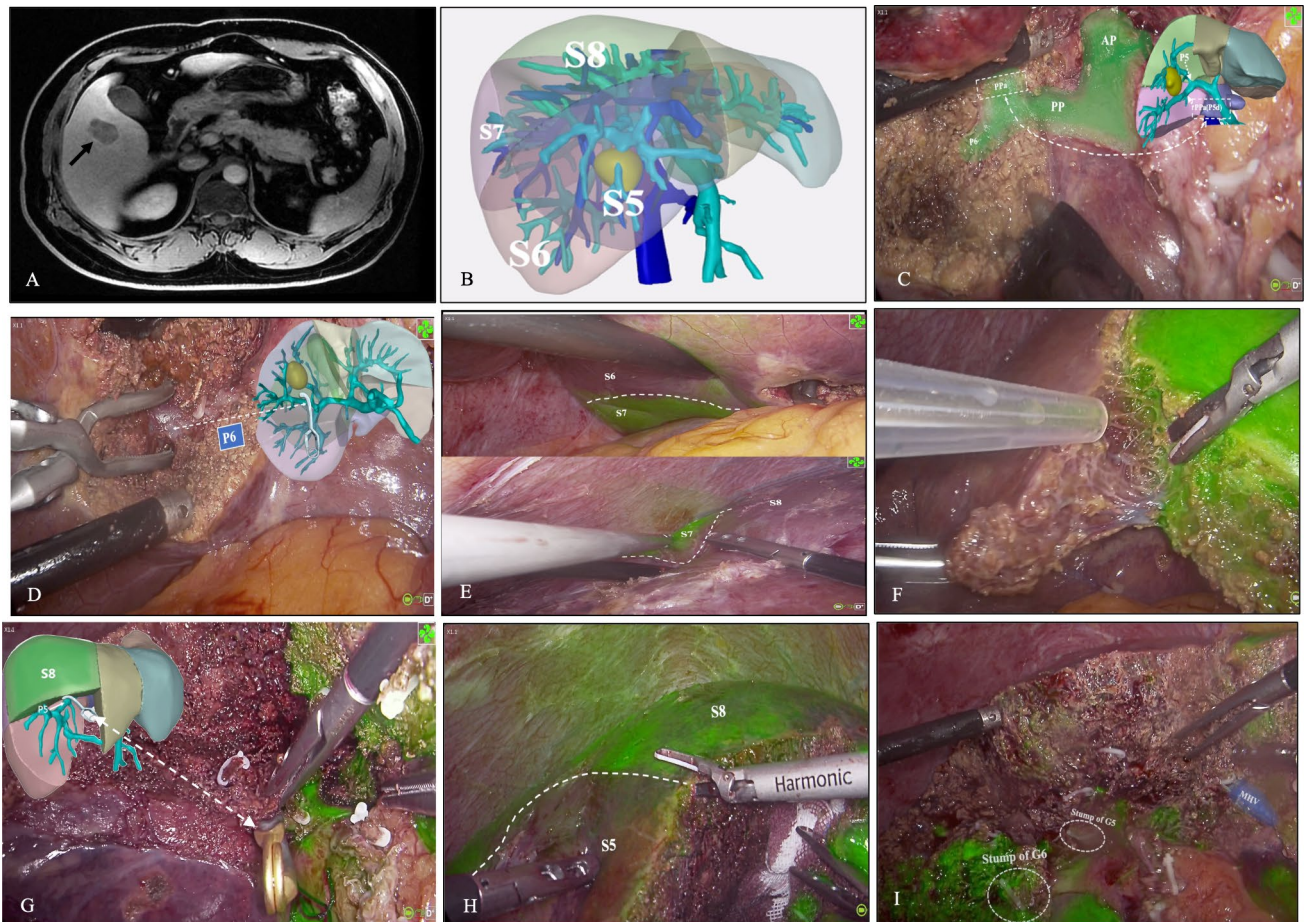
A A 44-year-old man with hepatitis B virus-related cirrhosis presented with a hypervascular nodule at the junction of hepatic segments 5 and 6 (black arrow) on magnetic resonance imaging which was highly suspicious for hepatocellular carcinoma. B A three-dimensional reconstruction showed the tumor was closely attached to branches G5 and G6 and was located between hepatic veins V5 and V6. C The pedicle of segment 6 (P6) and the dorsal pedicle of segment 5 (PPa) were exposed. D The PPa was transected and the anterior pedicle and P6 were isolated. E–F ICG-HSA was injected
